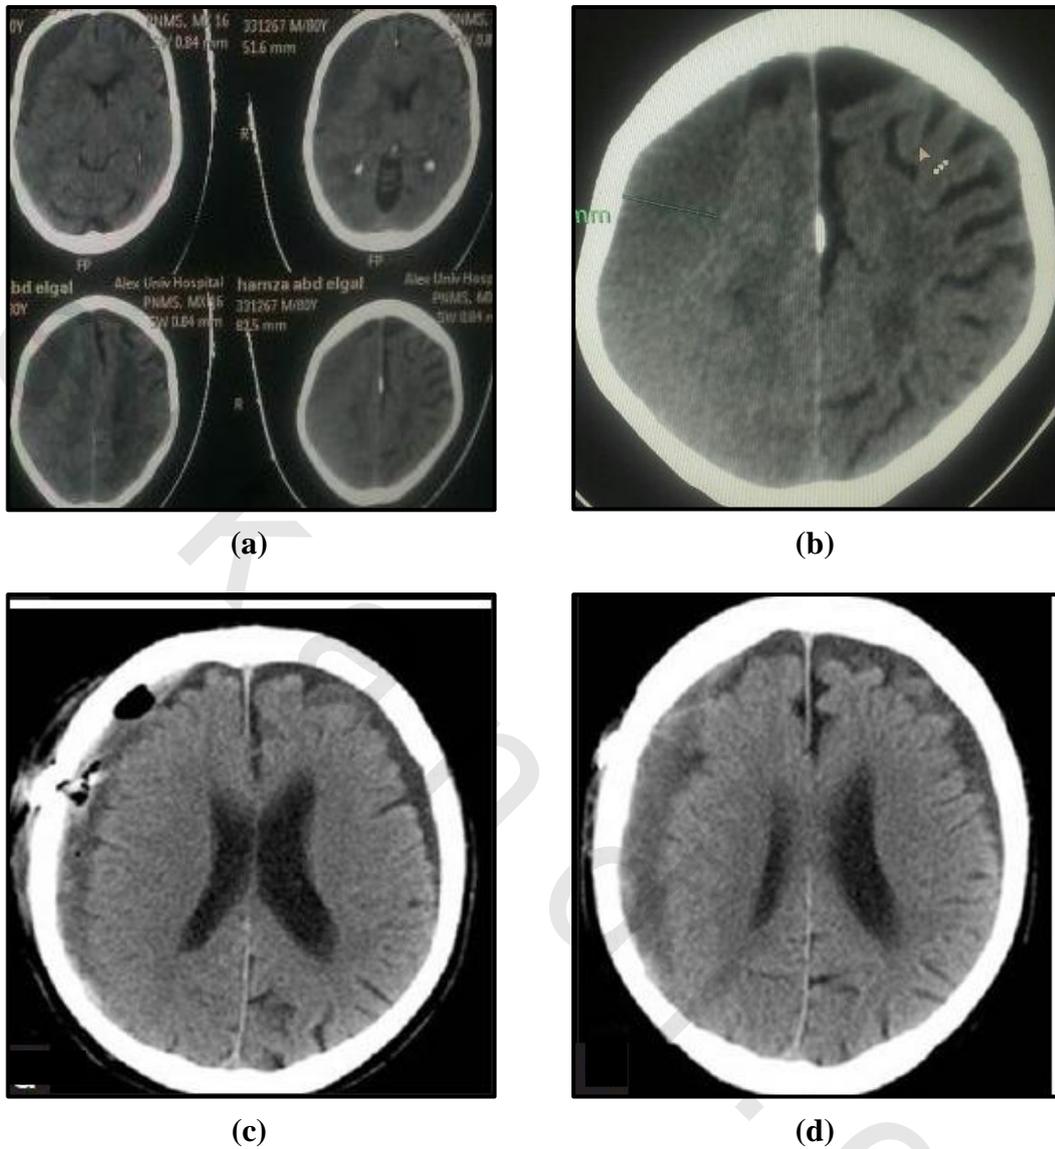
CT and MRI images. (a) Initial CT with a left-sided fronto-parietal chronic subdural hematoma of the separate type in 60 years male patient with hepatic dysfunction and on oral anticoagulant with history of mitral valve replacement since 5 years. (b) CT brain done after evacuation of the CSDH using tow burr holes and subcutaneous closed system drainage showing complete evacuation of the hematoma with no subdural air collection and no mid-line shift. (c,d) CT and MRI brain done 3 months after discharge of the patient because of recurrence of the symptoms (headache and right hemiparesis) showing recurrent CSDH.
